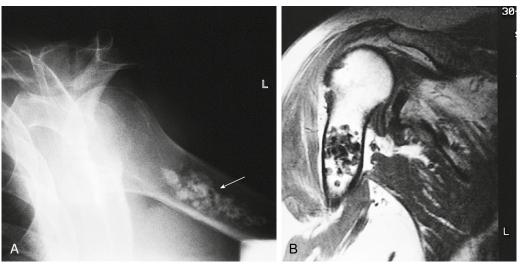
A, Conventional shoulder radiograph in a 66-year-old man demonstrates calcification in the proximal diaphysis of the right humerus *(arrow)*. B, Follow-up magnetic resonance image demonstrates an intramedullary lesion without breakthrough of the cortex, consistent with an enchondroma. (From American College of Radiology, Reston, Virginia.) (Riverside Methodist Hospital, Columbus, Ohio.)
